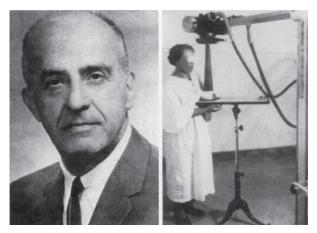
Jacob Gershon-Cohen (Courtesy of Radiology) Radiographic 1990; 10: 1111-1130
